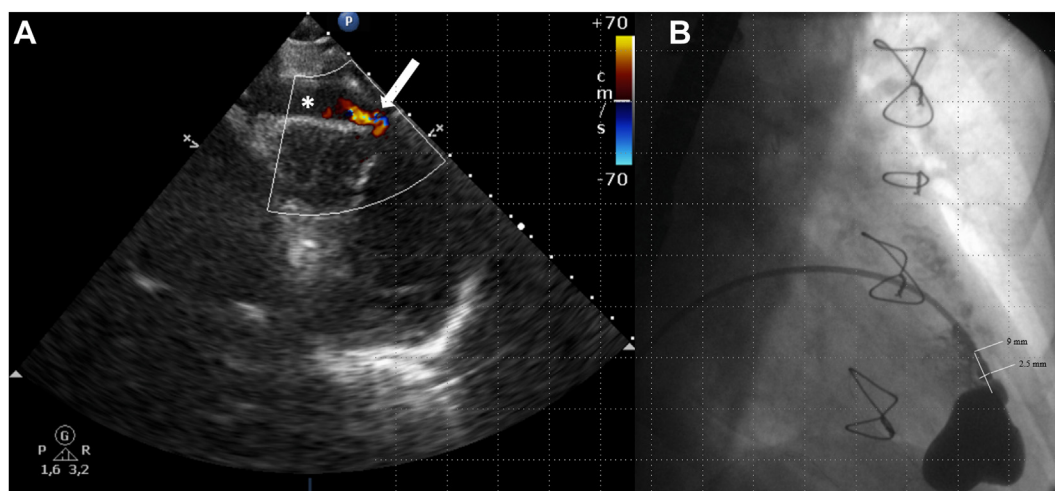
(A) Echocardiographic image of right ventricle pseudoaneurysm. The * shows the pseudoaneurysm; arrow shows its entrance. (B) Pseudoaneurysm of the right ventricle imaged in angiography with its sizes.
